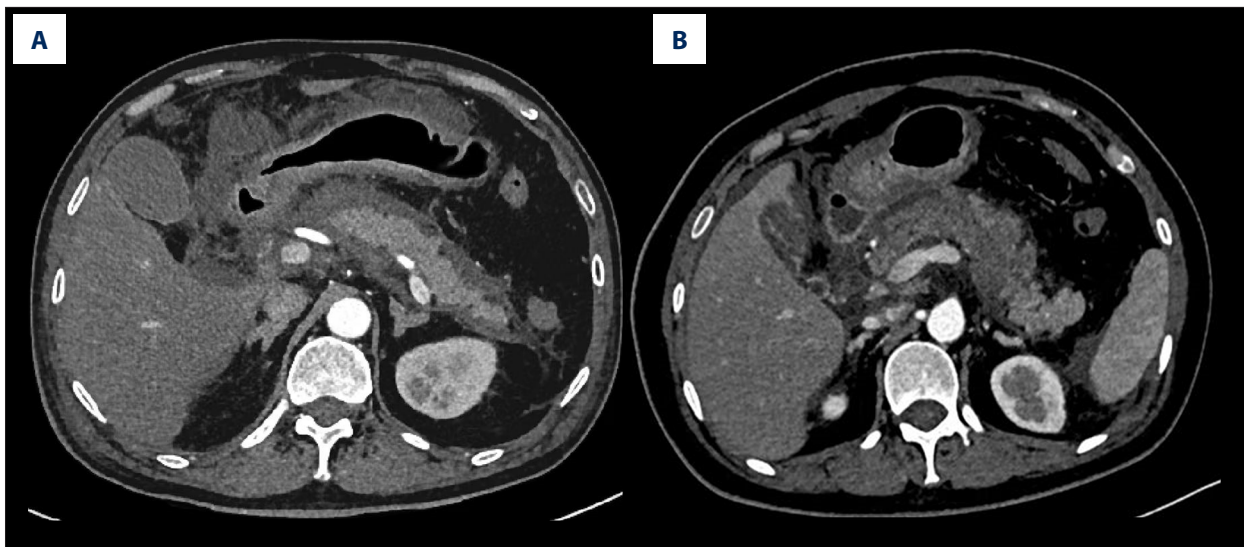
Representative CT images from 2 patients with acute pancreatitis. (A) CT image obtained at admission from a patient with moderate acute pancreatitis who did not develop diabetes mellitus during follow-up. CTSI = 4 and EPIC = 5. Pancreatic changes were limited to interstitial edema, and no pancreatic necrosis was observed. (B) CT image obtained at admission from a patient with moderate-to-severe acute pancreatitis who developed diabetes mellitus during follow-up. CTSI = 8 and EPIC = 7, with 30% to 50% pancreatic necrosis observed. CT, computed tomography; CTSI, computed tomography severity index; EPIC, extrapancreatic inflammation on CT score.
